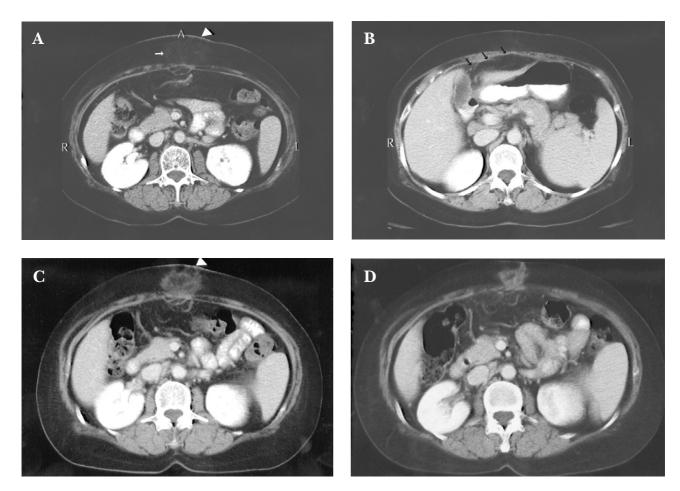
(A) Axial computerized tomography (CT) image with contrast enhancement 1 month after transcatheter arterial chemoembolization (TACE) shows thickening of the supraumbilical skin (arrowhead) associated with increased-density subcutaneous fat (arrow). (B) Axial CT image obtained 7 cm cranial to that in (A). The connective tissue along the falciform ligament (arrows) is expanded with infiltration and the left hepatic lobe is downwardly displaced. (C) Axial CT image with contrast enhancement 3 months after TACE. Interval shrinkage of the affected skin area (arrowhead) and a subcutaneous high-density nodule are evident. (D) Axial CT image with contrast enhancement 1 year after TACE. The subcutaneous high-density nodule measures about $2 \times 2.6 \times 2.7$ cm. The supraumbilical skin remains thickened but is significantly decreased in surface area.
